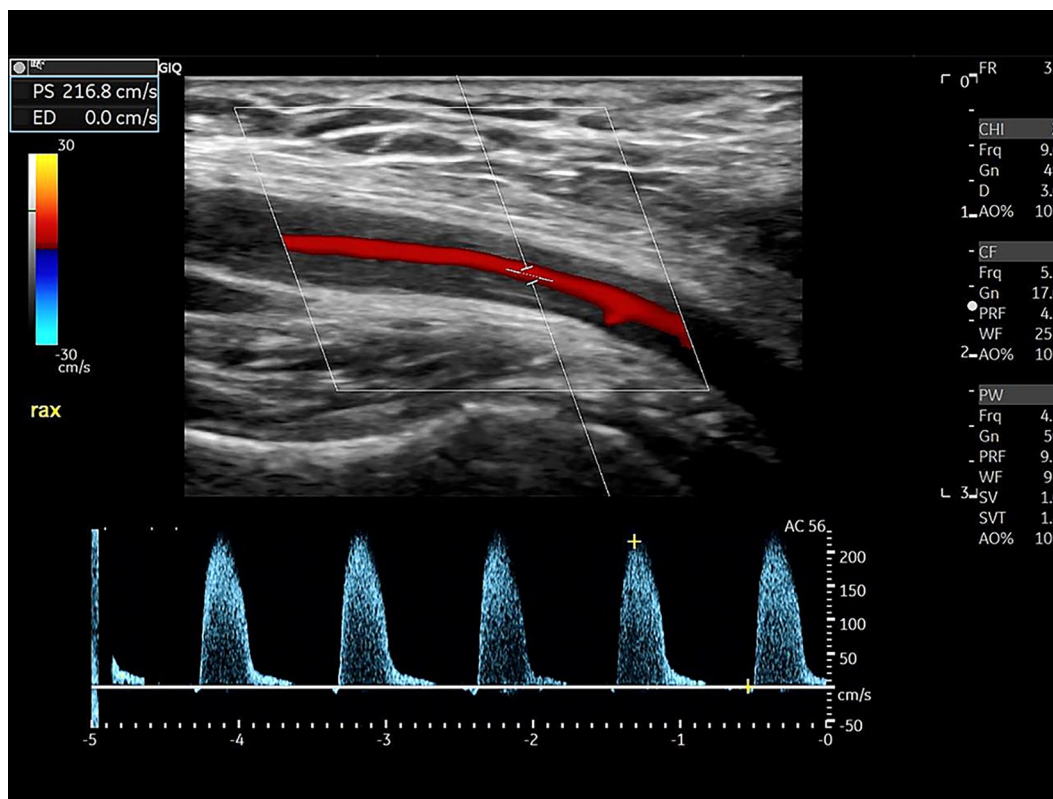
Pulsed-wave Doppler curves in the same artery as in Figure 4, typical for stenosis. Peak systolic flow velocity is elevated (217 cm/s), the spectrum is broader, and the systolic flow velocity increases more slowly while remaining high for a longer duration. The colour signal exhibits no aliasing because the PRF is adjusted for high velocity (9.1 kHz). PRF, pulse repetition frequency.
